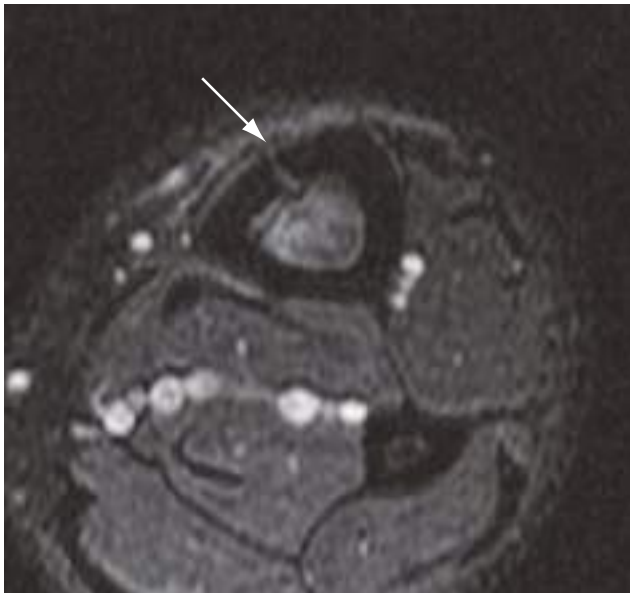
Some stress fractures are oriented longitudinally. This axial fat-suppressed T2-weighted MR image shows interruption of the anterior tibial cortex (*arrow*). This finding was present on multiple consecutive images. Radiographs were normal.
